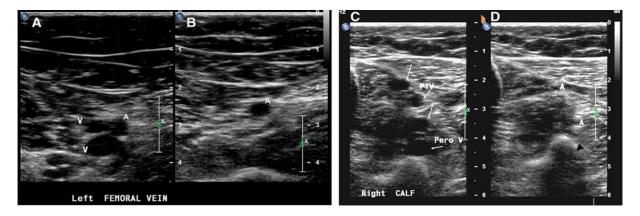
Duplex ultrasound (US) for Acute Pulmonary Embolism (14)
